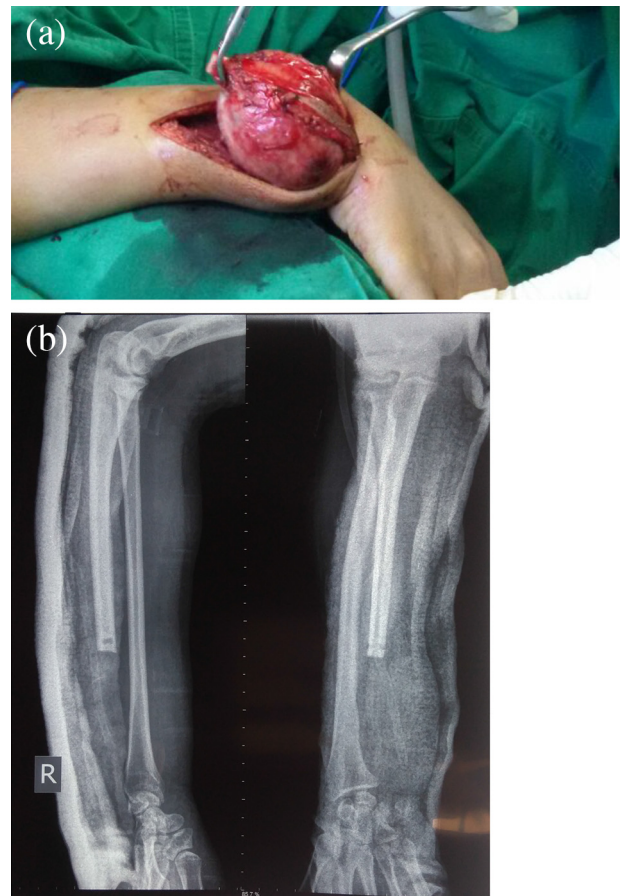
a) Operative photograph showing a large tumor originating from the right ulna (case 2). b) AP & lateral radiograph of right lower arm postoperative (case 2).
